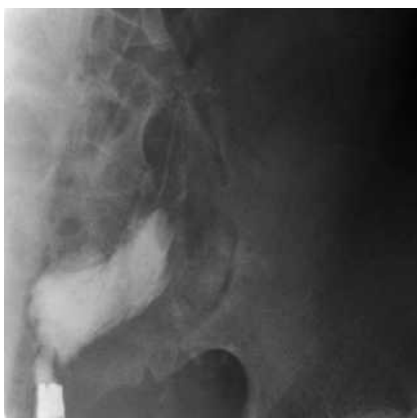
Radiograph showing the gastroscope, transrectal puncture of the descending colon, and injection of water-soluble contrast verifying the position of the needle in the descending colon.
